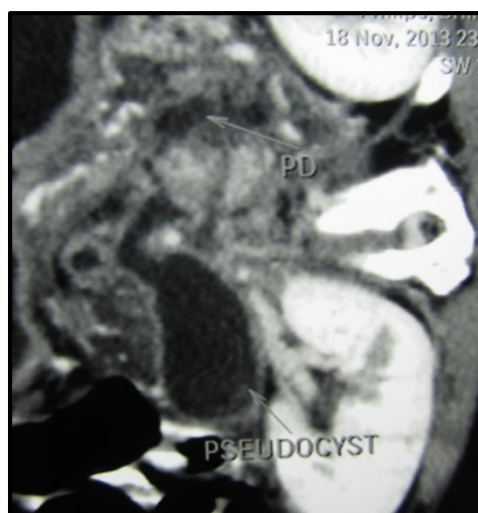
CT scan: Small atrophic pancreas with dilated pancreatic duct. Multiple small intrapancreatic & peripancreatic pseudocysts.
